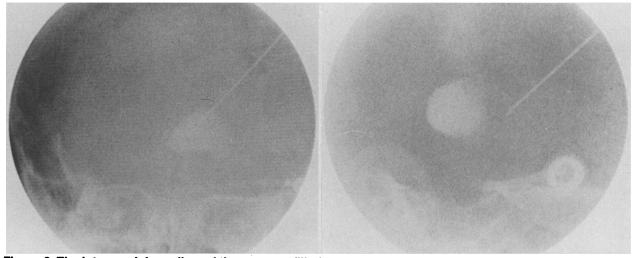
The intracranial needle and the contrast-filled cyst just prior to final aspiration and ³²P injection are seen on intraoperative anterior-posterior (left) and lateral (right) skull x-ray films
